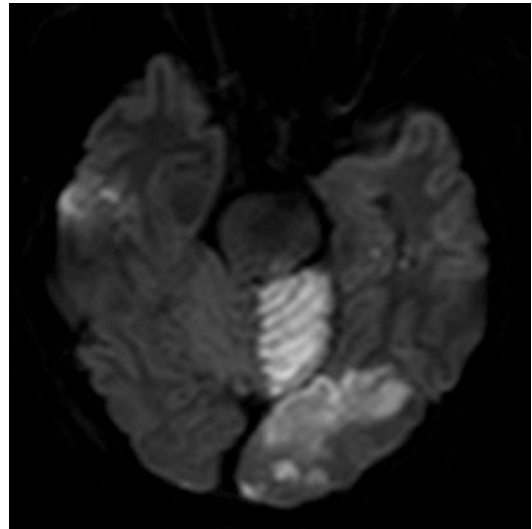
A 56-year-old, previously healthy man developed dysarthria and left ataxia 1 day after coil embolization for basilar tip aneurysm. Diffusion-weighted MRI showed infarcts in the right superior cerebellar artery and posterior cerebral artery territories, which were probably related with the therapeutic procedure
